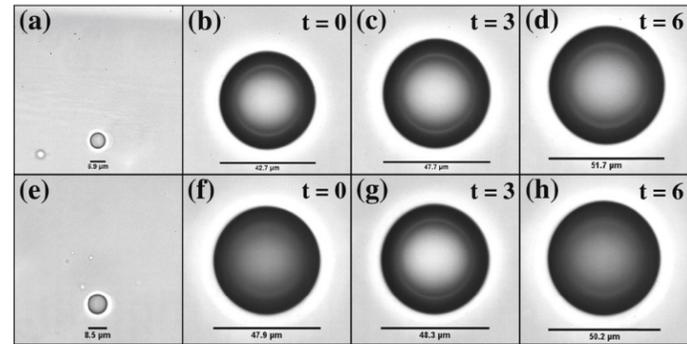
Acoustic droplet vaporization (ADV) of individual phase-change microdroplets with ultrasound. a and e: Before images of microdroplets. b-d and f-h: Observed bubbles seconds after phase change. Reprinted with permission from Sheeran et al. (2011).
